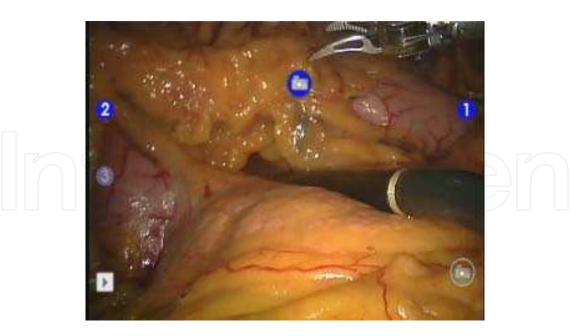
intraoperative laparoscopic ultrasonography is applied to identify the exact location of the pancreatic tumor.
